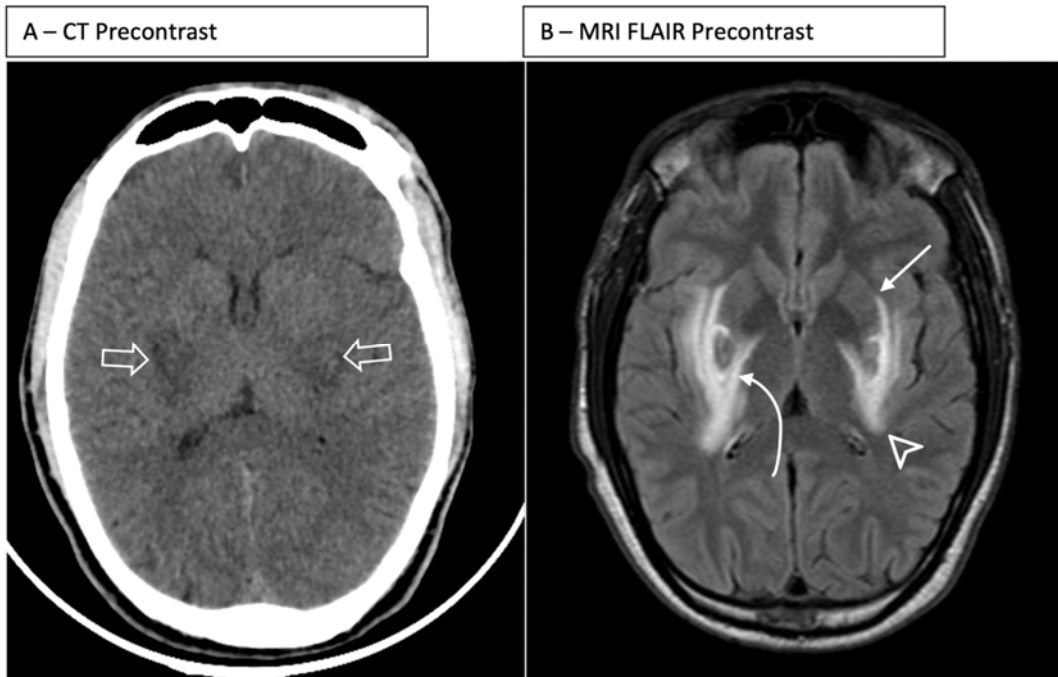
CT and MRI brain
